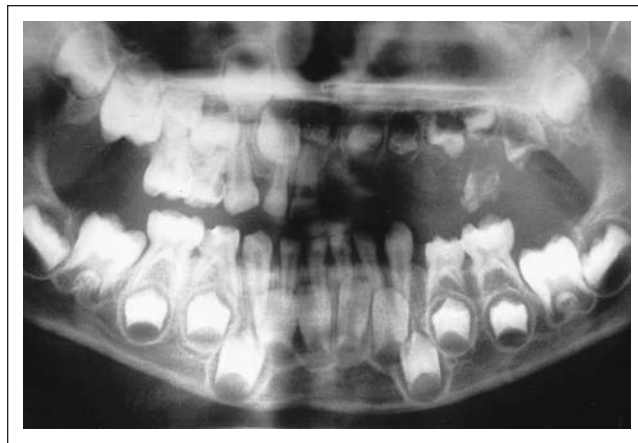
Panoramic radiograph shows the teeth with "ghostly" appearance in maxillary left quadrant. All teeth are normal except in left maxillary quadrant.
